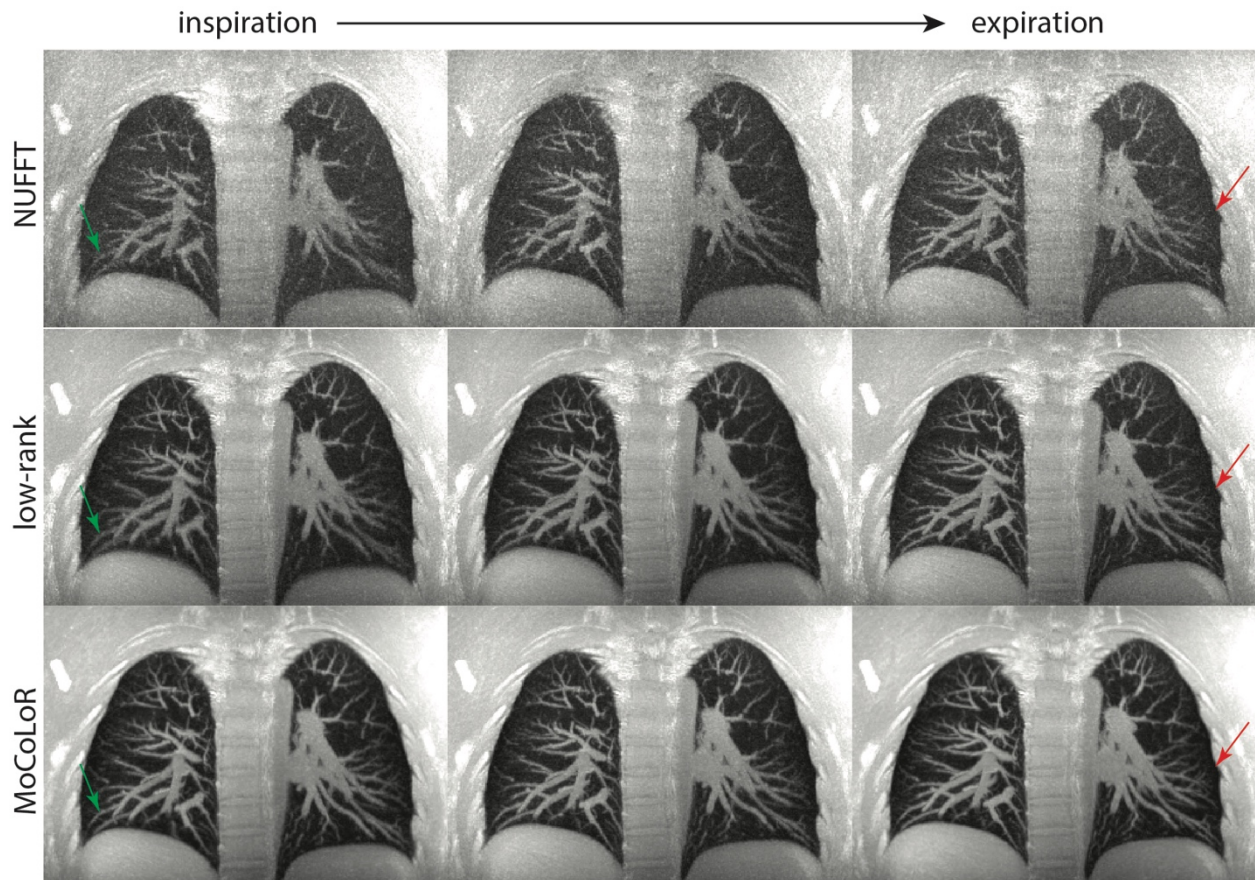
Healthy volunteer lung MRI study. Maximum intensity projection of 30 coronal slices reconstructed with the three methods are generated to compare performance among different reconstructions.
